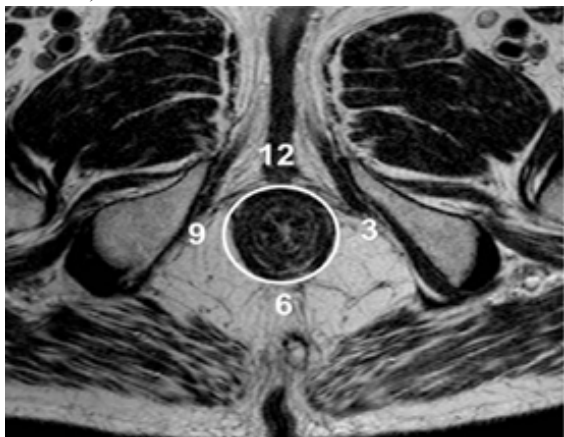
Axial T2-weighted MR images shows the "anal clock". The anterior perineum is located at 12 o'clock and the posterior midline or intergluteal cleft is at 6 o'clock, while the left lateral aspect of the anal canal is at 3 o'clock and the right lateral aspect is at 9 o'clock.
